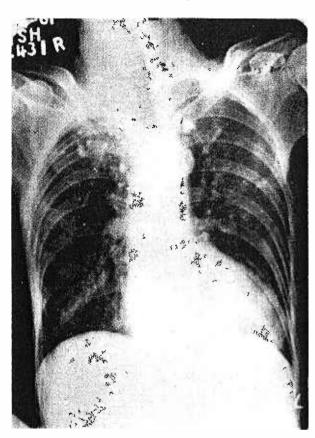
The X-ray film of the chest showing the enlarged heart mainly of the left ventricle.
